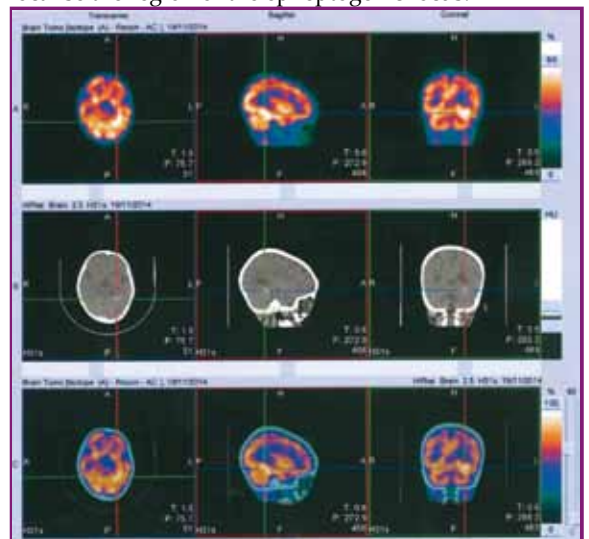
Patient with left inferior temporal calcified cortical dysplasia which showed hyperperfusion during clinical seizure in Ictal SPECT scan
